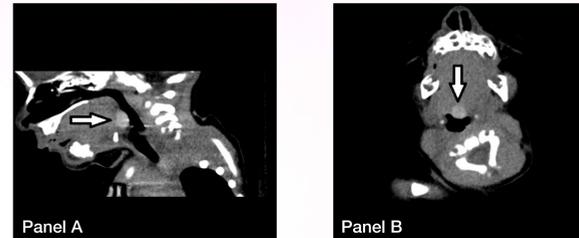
A noncontrast CT of the neck. Panel A, sagittal view; Panel B, axial view. White arrows denote lingual thyroid.
